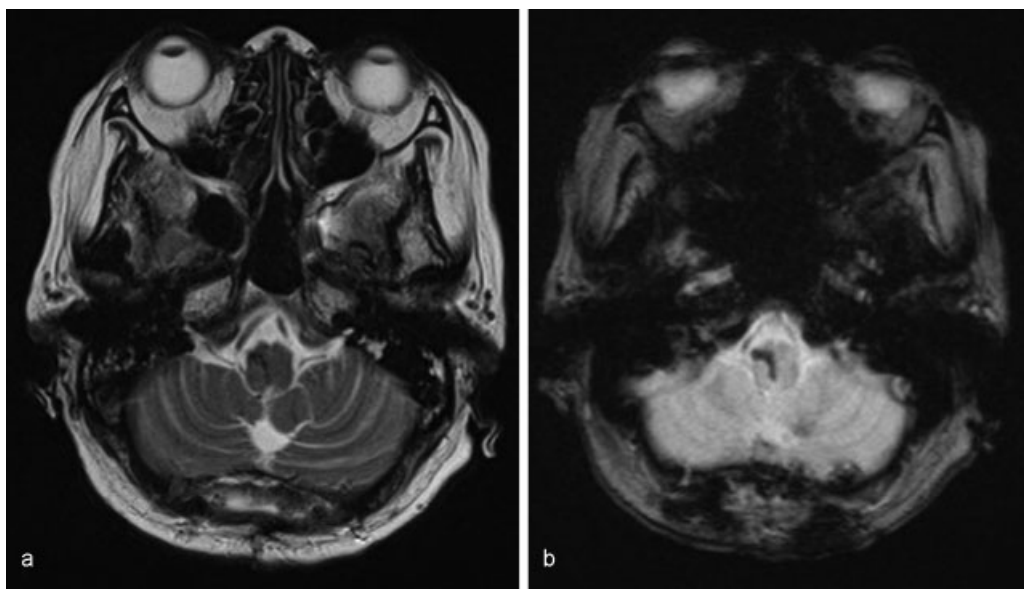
Postoperative magnetic resonance images 5 weeks after surgery revealed no structural abnormality. (a) T2 weighted. (b) T2* weighted.
